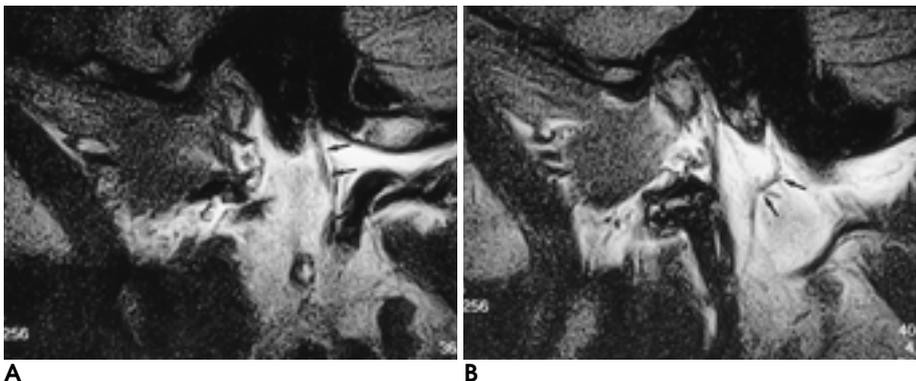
23-year-old man with post-traumatic the Lt. facial palsy. MR images were obtained 18 weeks after onset of symptoms. Oblique sagittal T1WI without contrast administration.
